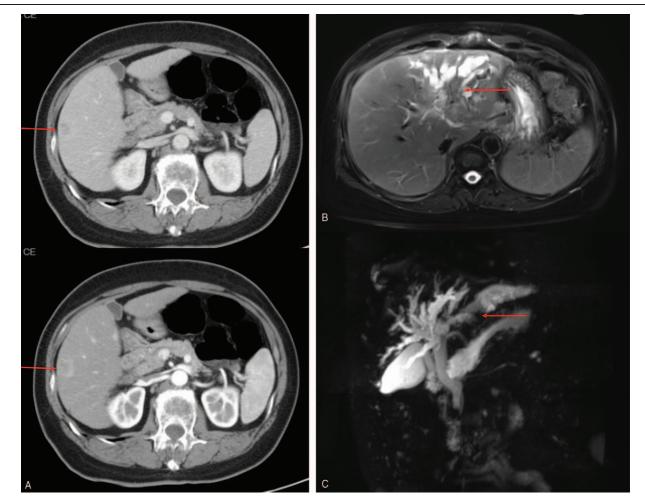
The preoperative images of patients with sarcomatous intrahepatic cholangiocarcinoma (SIC) with typical changes. (A) The computed tomography images of a patient with SIC showed a hypodense hepatic lesion with peripheral enhancement (arrow). (B) The magnetic resonance imaging image of a patient with SIC showed a low-intensity hepatic lesion on T2 weighted image (arrow). (C) The magnetic resonanced cholangio-pancreatography image of a patient with SIC showed a low-intensity lesion in hepatic duct, with dilation of corresponding bile ducts (arrow).
